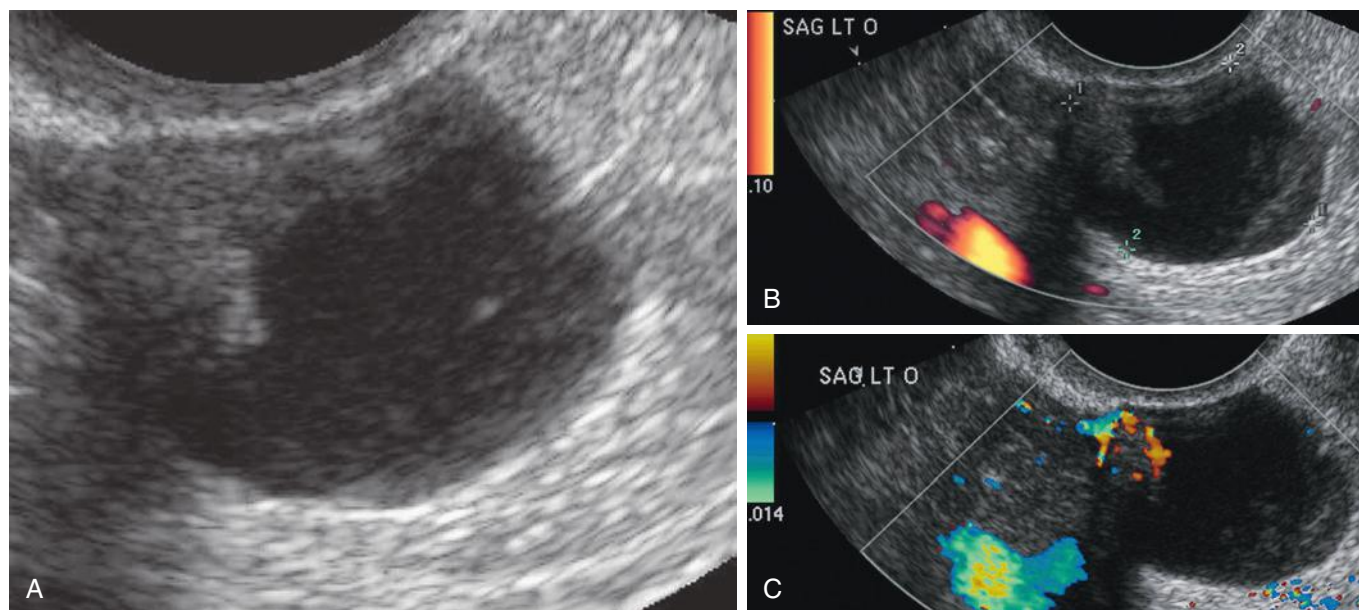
A, Cystic ovarian lesion with moderately echogenic, possibly solid mural component. B, No convincing blood flow is shown within cystic ovarian lesion on initial power Doppler sonographic images. C, Blood flow is shown within solid mural nodule using color Doppler sonography with adjusted settings (including low-scale pulse repetition frequency) optimized to detect low flow.
